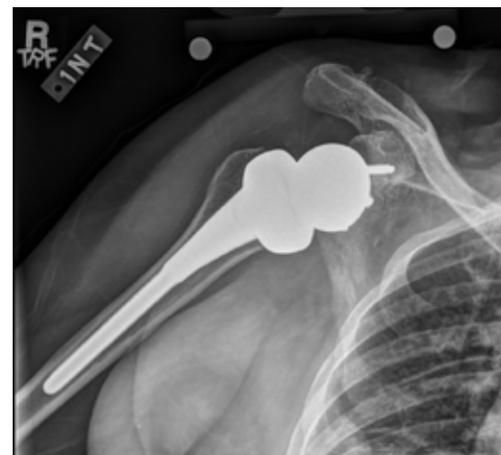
A&B Anteroposterior (A) and axillary (B) radiographs after reverse shoulder arthroplasty implanted along the alternative scapular spine centerline
